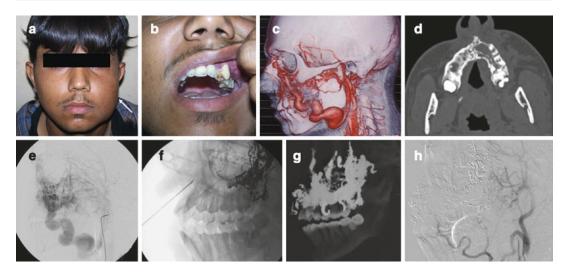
Eighteen- year-old boy with gum bleeds. (a, b) Clinical photograph showing left cheek swelling. Intramural view shoeing the site of gum bleed adjacent to the left upper incisor. (c) CT angiogram reconstructed views show the malformation within the maxilla with large hypertrophied draining vein. (d) Axial CT shows a lytic lesion in the left maxilla extending across the mid-line. (e) Left ECA angiogram shows high flow intraosseous AVM in the left maxillary alveolar process supplied by multiple hypertrophied alveolar and nutrient branches
